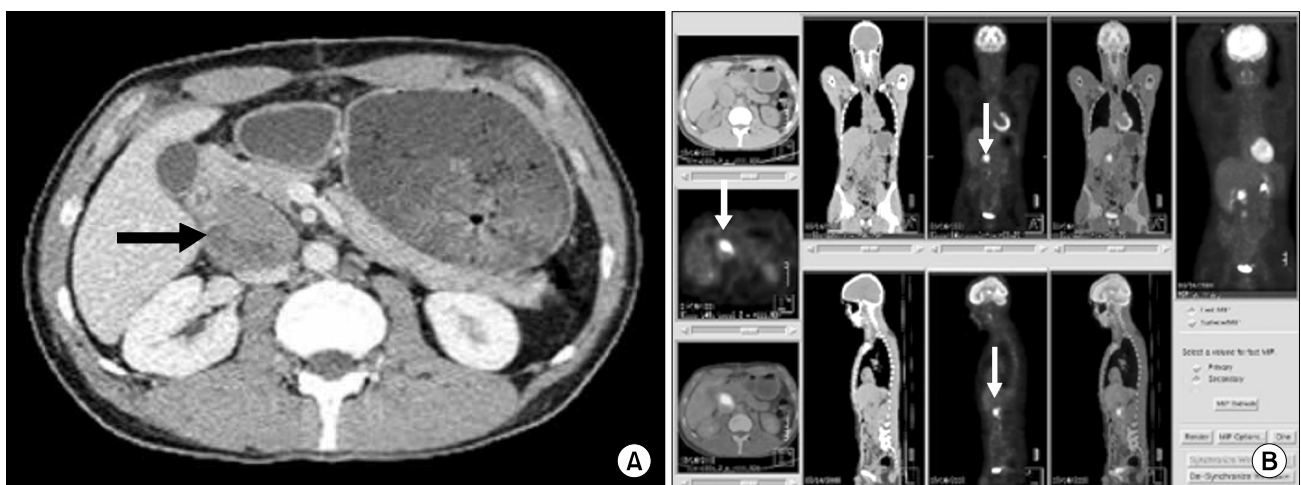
(A) Computed tomography (CT) of the retroperitoneum shows an enhanced mass (black arrow) with a lobulated margin and necrotic portion located between the pancreatic head and the inferior vena cava. (B) Proton emission tomography (PET) shows 2 hypermetabolic masses between the duodenum and the inferior vena cava (white arrow).
